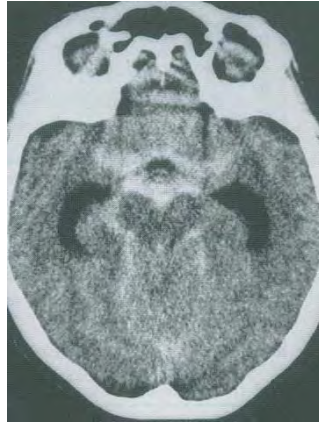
Computed tomography (CT) scan of diffuse subarachnoid haemorrhage (SAH) with communicating hydrocephalus (large temporal horns of the lateral ventricles); reprinted with permission from NET SMART ([www.learnstroke.com](http://www.learnstroke.com)), Health Outcomes Institute, LLC.
